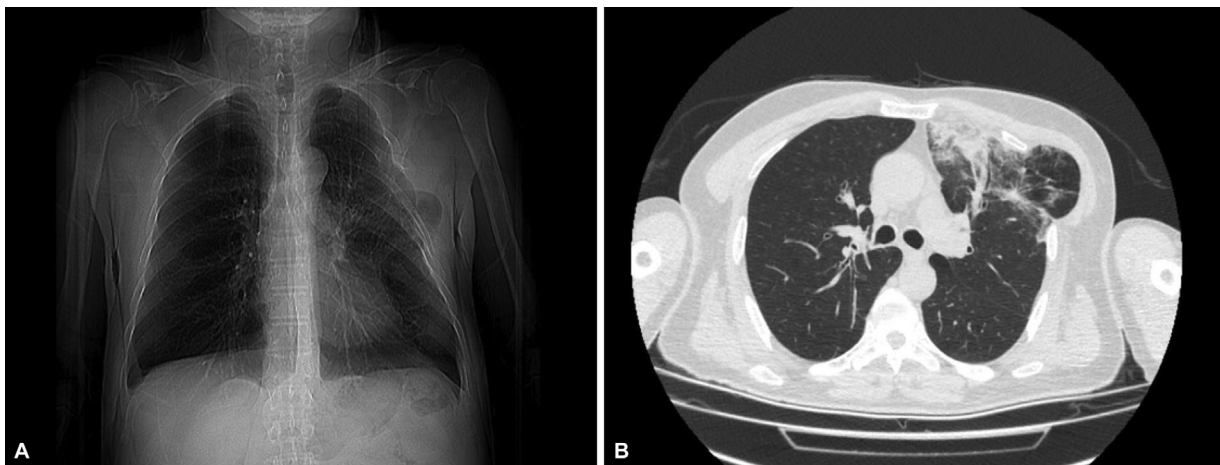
(A) Chest X-ray posteroanterior (PA) view showing lung margins and radiolucency beyond the rib cage borders in the left midzone of the hemithorax. (B) Noncontrast-enhanced axial computed tomography (CT) image demonstrates the intercostal lung herniation through the fourth intercostal space. Also, consolidation with ground-glass opacities is seen.
